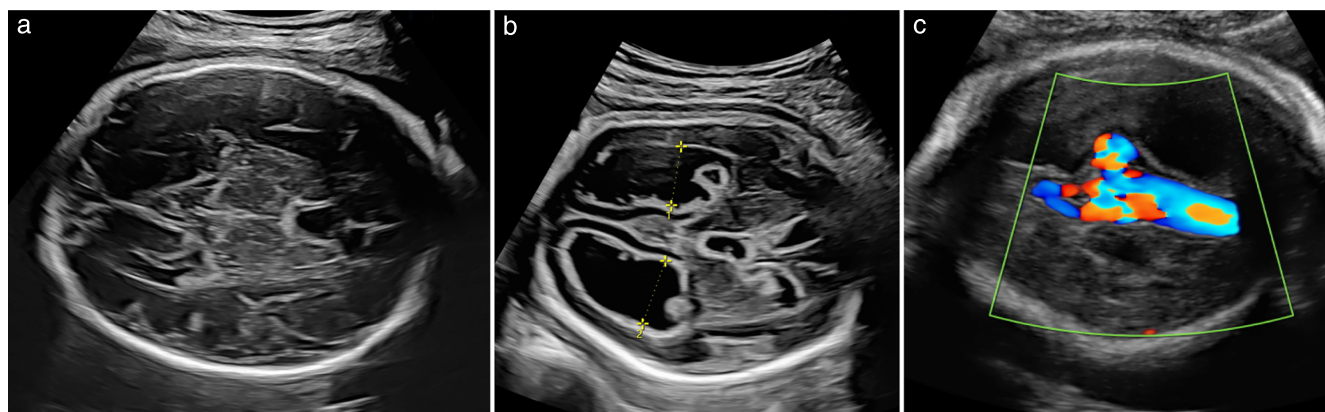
(a) Normal fetal brain configuration on ultrasound imaging in third trimester. (b) Dilatation of third and lateral ventricles, with intraventricular echogenic material (intraventricular hemorrhage Grade 3). (c) Color flow in tubular area that appeared anechoic on B-mode imaging, at midline in posterior part of base of skull (vein of Galen aneurysm).
